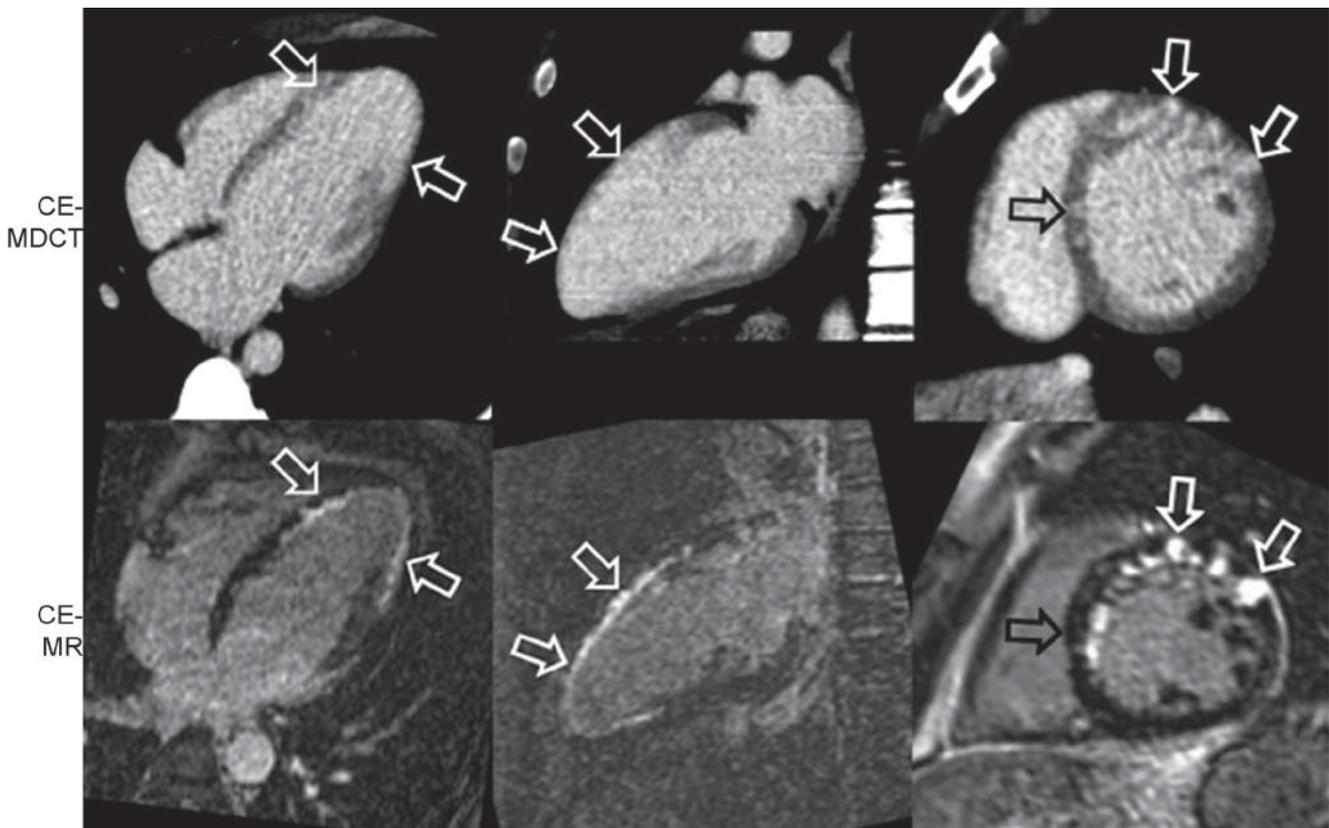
Examples of late MDCT and corresponding CE MRI images in a patient with acute myocardial infarction 25 days earlier. CE contrast enhanced. Reproduced from Gerber et al.²⁸ with permission
